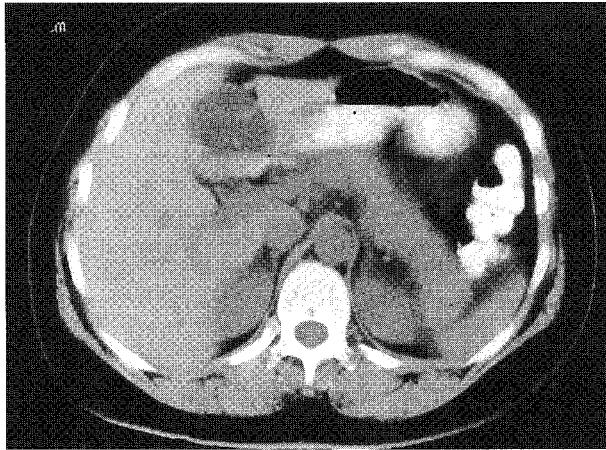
Nonenhanced CT of the liver shows well-defined, spherical, low-density mass. Internal septations are poorly visible.
